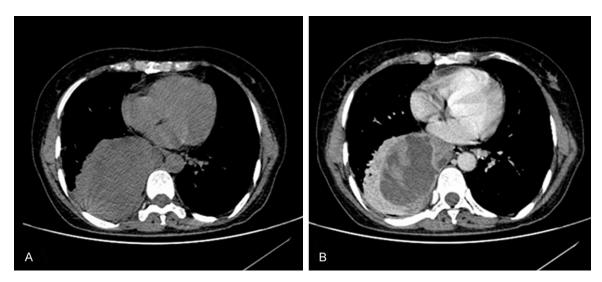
Chest computed tomography images. (A) axial pain and (B) axial contrast-enhanced views show a large mass with heterogeneous enhancement and predominantly cystic areas surrounded by atelectatic lung tissue in the right hemithorax.
